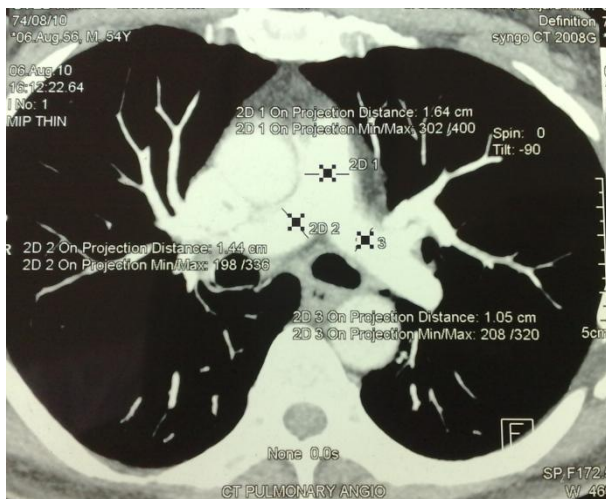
CT scan showing dilated pulmonary arteries.
